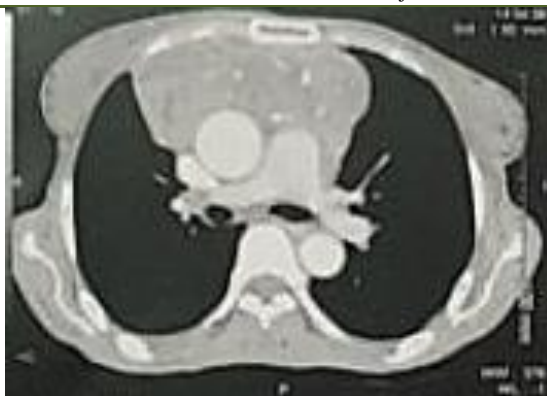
Follow-up thoracic CT scan indicates a quasi-stable appearance of the thymoma
